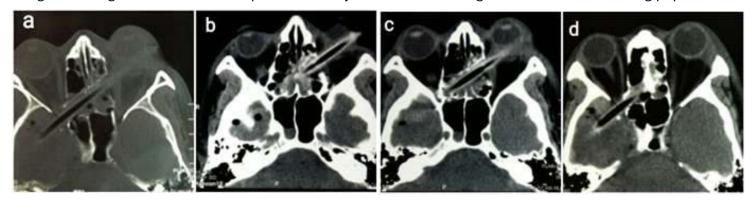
The CT orbit report revealed that a large 11cm \*0.5 cm wooden foreign body
